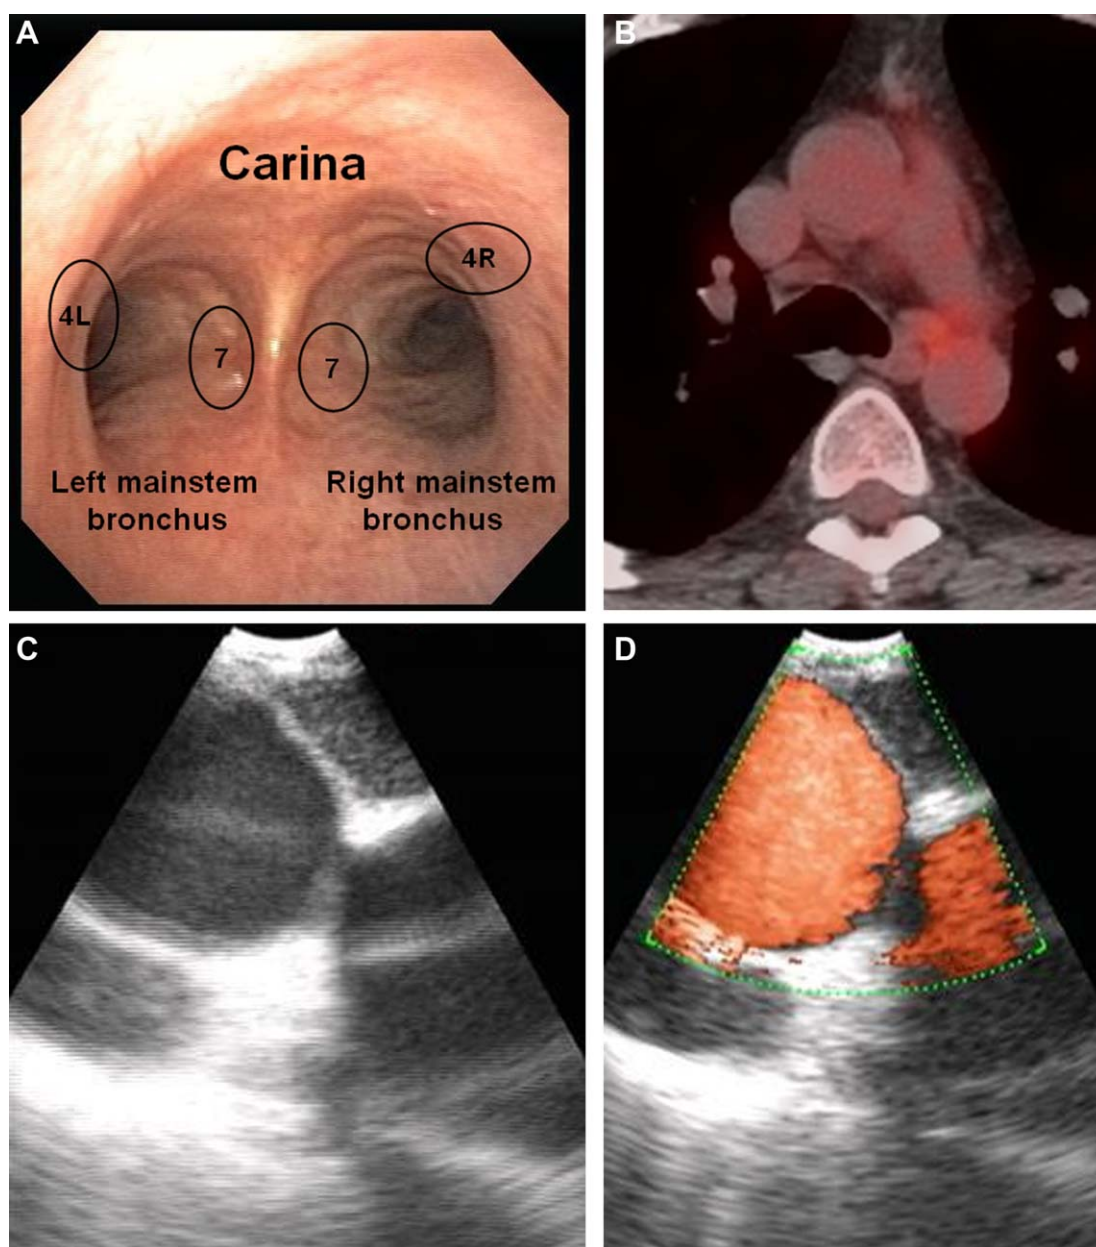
(A) This is an endobronchial view of the distal trachea. Labels indicate that the carina separates the right (R) and left (L) main bronchi. The subcarinal or lymph node station 7 can be accessed at the medial wall through either the right or left main bronchi. Station 4L is observed at the 9 to 10 o'clock position, proximal to the main carina. (B) This positron emission tomography-computed tomography image at the level of the carina demonstrates significant 2-deoxy-2-(18F)fluoro-D-glucose uptake at station 4L at the aortopulmonary window. (C) Endobronchial ultrasound images demonstrate the location of superficial lymph node station 4L and the flanking vessels: the aorta and left main pulmonary artery seen as anechoic (black) structures. (D) The use of Doppler allows the operator to clearly identify vascular structures. The fully colored vessel is the left main pulmonary artery, and the other vessel is the aorta. Lymph node station 4L can be seen clearly as a hypoechoic (gray) structure on the surface.
